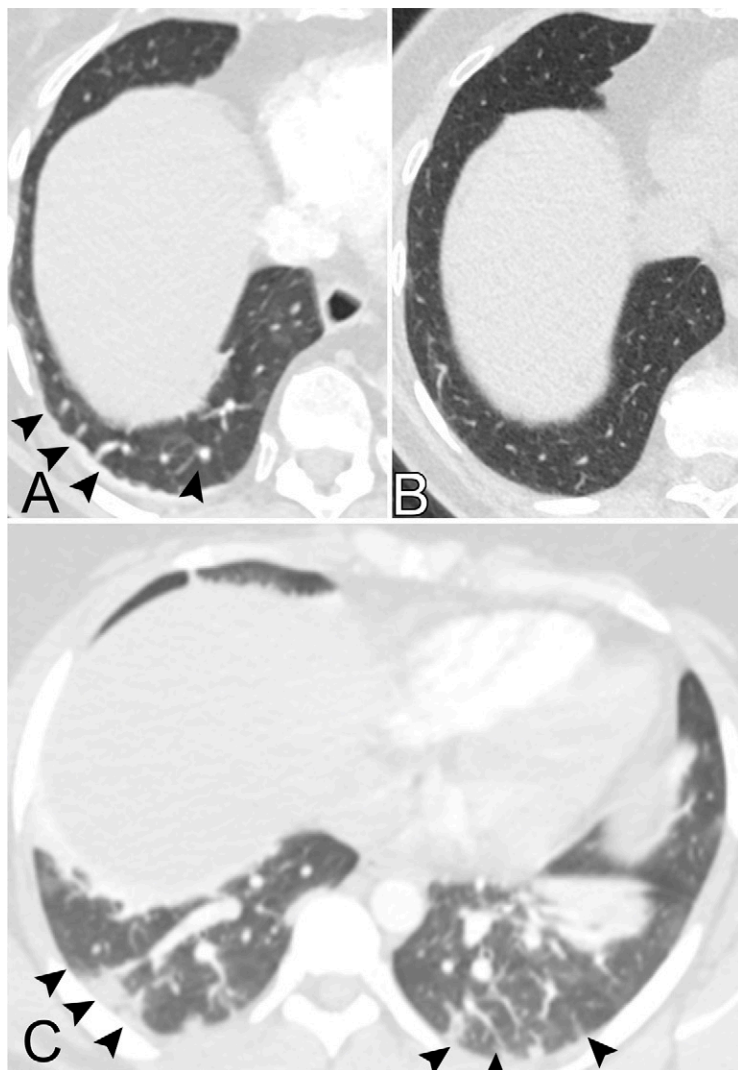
A, Image in an 84-year-old woman with a history of breast cancer who presented to the emergency department for fever, weakness, altered mental status, acute shortness of breath, and chest pain, for which CT pulmonary angiogram was obtained. Axial CT image shows dilated, nontapering, tortuous vessels in the posterior right lower lobe (arrowheads), some of which extend to the pleural surface. B, CT scan in the same patient shown at the same level 5 months prior shows normal vessels. C, Image in a 27-year-old woman who presented to the emergency department with acute shortness of breath and dyspnea on exertion. Patient was subsequently found to be coronavirus disease 2019–positive and had worsening tachypnea. Axial CT image through the lower lobes shows multiple dilated tortuous vessels within the lower lobes, with extension to the pleural surfaces (arrowheads).
